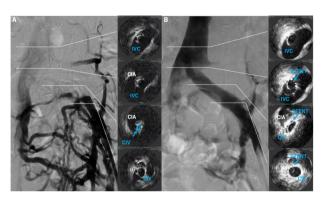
Images of venography and intravascular ultrasound (IVUS) before and after stenting of the left common iliac vein (LCIV) (A, B). The preoperative venography via left femoral vein demonstrated left-to-right pelvic collaterals and an enlarged ascending lumber vein (A). IVUS showed wall thickening and intraluminal irregularity of the LCIV and extrinsic compression by the adjacent right branch of the vascular prosthesis prior to stenting (A). Postoperative venography showing the patent left iliac vein and diminished left-to-right collaterals (B). Even with the indentation in the middle of the stent, the lumen was wider than before stenting (B).
